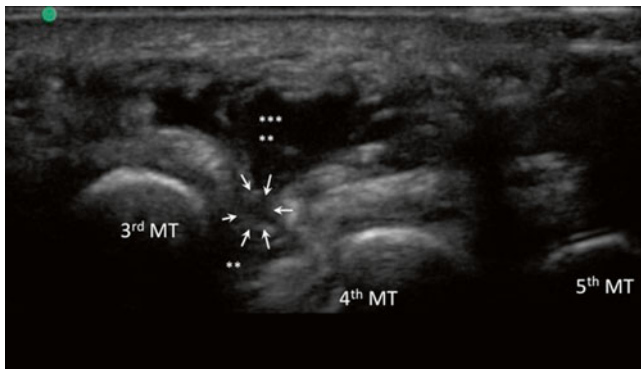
Sonography of the Morton's neuroma (*line arrows*) following the hydrodissection with local anesthetic (). The picture is the short axis view of the forefoot when the ultrasound probe was applied over the metatarsal heads on the plantar surface of foot. MT-metatarsal (Reproduced with permission from Philip Peng Educational Series)
